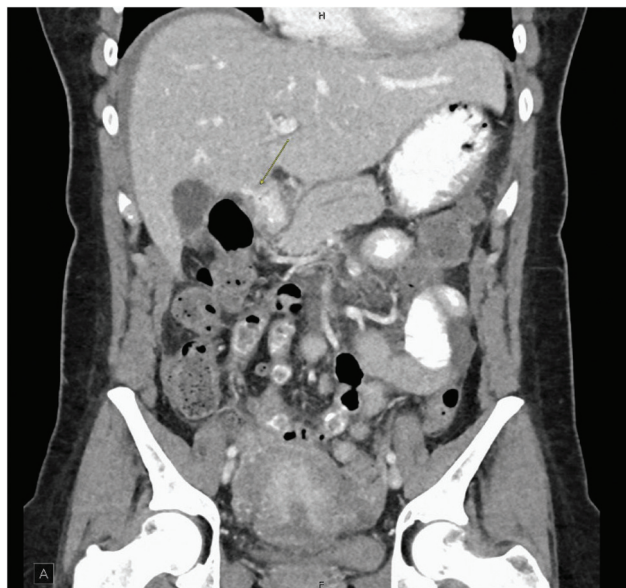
Patient B's coronal CT of the abdomen and pelvis demonstrating small volume pneumoperitoneum and abdominopelvic ascites with focal extravasation of oral contrast at the duodenal bulb (yellow arrow) and layering adjacent to the liver in the porta hepatis, consistent with duodenal ulcer perforation. CT, computed tomography.
